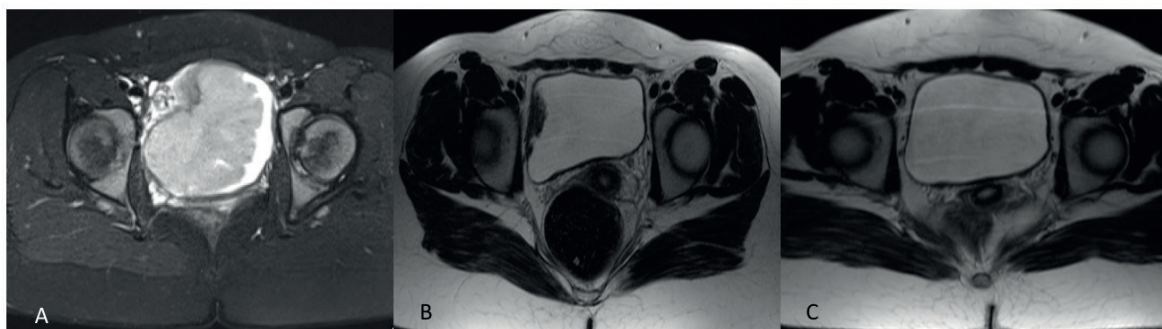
(A) Initial MR image of bladder mass; T2 weighted fat saturated axial MR image shows hyperintense solid mass with lobulated contour, extending into the bladder lumen. (B) T2 weighted axial image reveals marked regression of the lesion after 2 cycles of induction chemotherapy and (C) total resolution after the end of the treatment.
